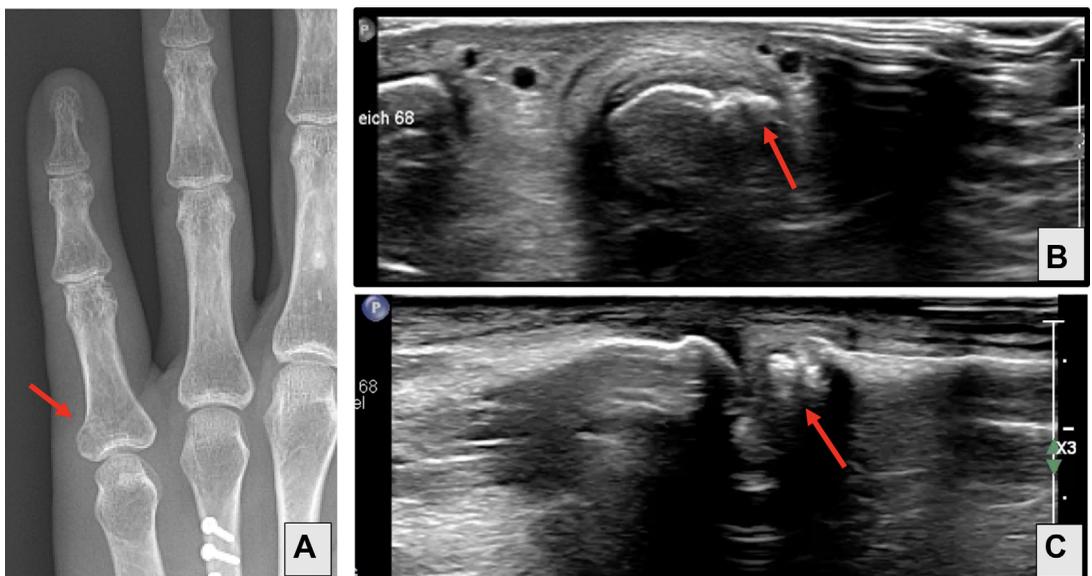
Arrows pointing to fracture. (A) Radiograph without obvious fracture of proximal phalanx. (B) Axial view of dorsoulnar fracture. (C) Longitudinal view of dorsal fracture.
